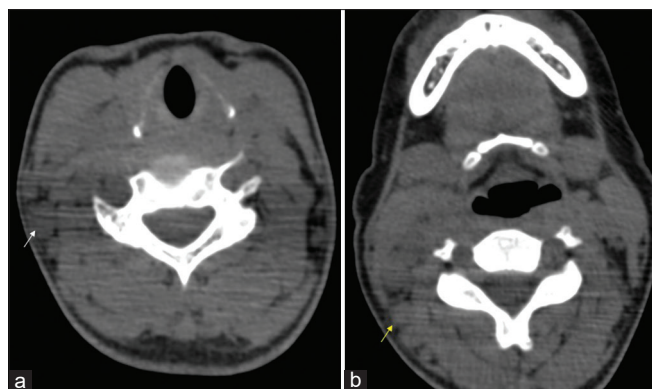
Computed tomography scan of neck and upper chest; marked asymmetrical cervical and supraclavicular lymphadenopathy more on the right side (arrow in a and b).
